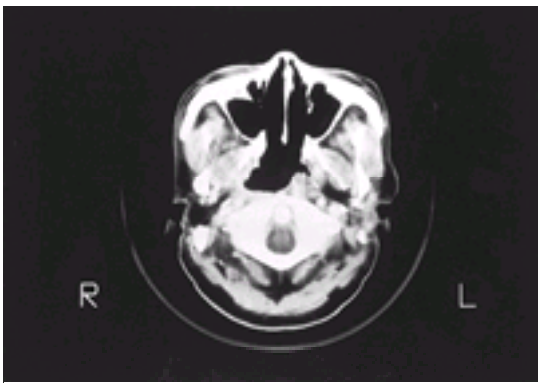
CT scan appearance after transoropalatal right nasopharyngectomy for recurrent nasopharyngeal carcinoma in a 33-year-old man.
